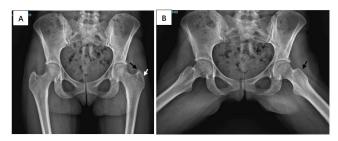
Early osteophytes formation over tip of the greater trochanter (GT) and roughness of the lateral surface of the GT (A, arrows) on AP radiograph and anterior aspect of the GT on front lateral view radiograph (B an arrow).
